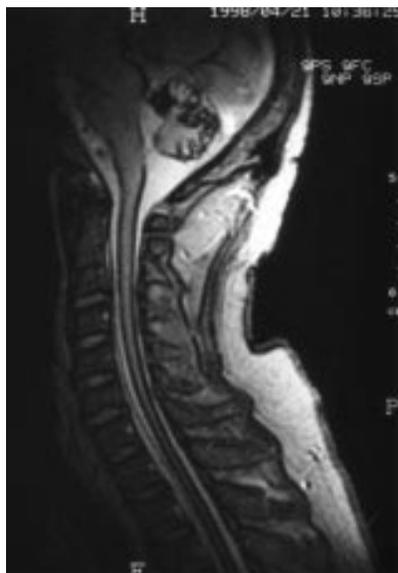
T2 weighted MRI demonstrating the characteristic rim of hypointensity around the posterior fossa and spinal cord seen in superficial siderosis.
